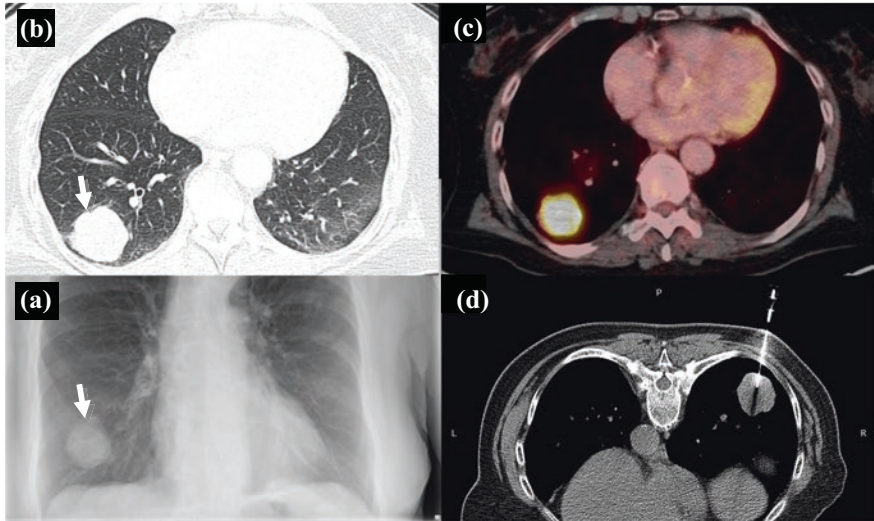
A 70 year-old female presented with cough and haemoptysis and was referred for chest radiograph. a Chest radiograph shows a round mass-like opacity projected in the right lower lung (Arrow). b CT with lung windows shows a corresponding mass in the right lower lobe (Arrow). c Fused PET and CT images of thorax demonstrate increased activity in the mass, often described as appearing ‘hot’. d CT guided biopsy of the mass with patient positioned prone, therefore appearing on the other side
